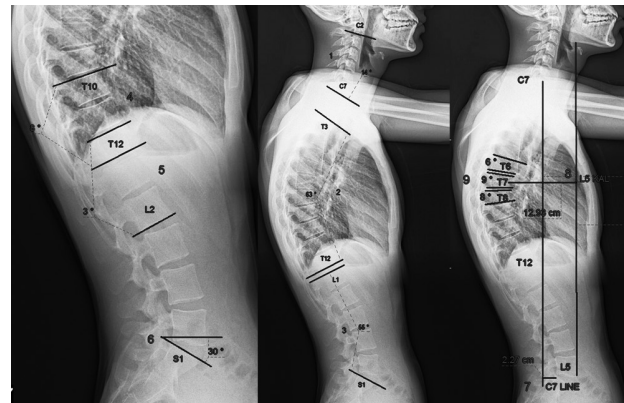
Radiographic measurements. 1, cervical lordosis angle; 2, thoracic kyphosis angle; 3, lumbar lordosis angle; 4, T10–T12 Cobb angle; 5, T12–L2 Cobb angle; 6, sacral slope angle; 7, C7 plumb line; 8, L5-kyphosis apex line; 9, number and location of the anteriorly wedged vertebrae.
